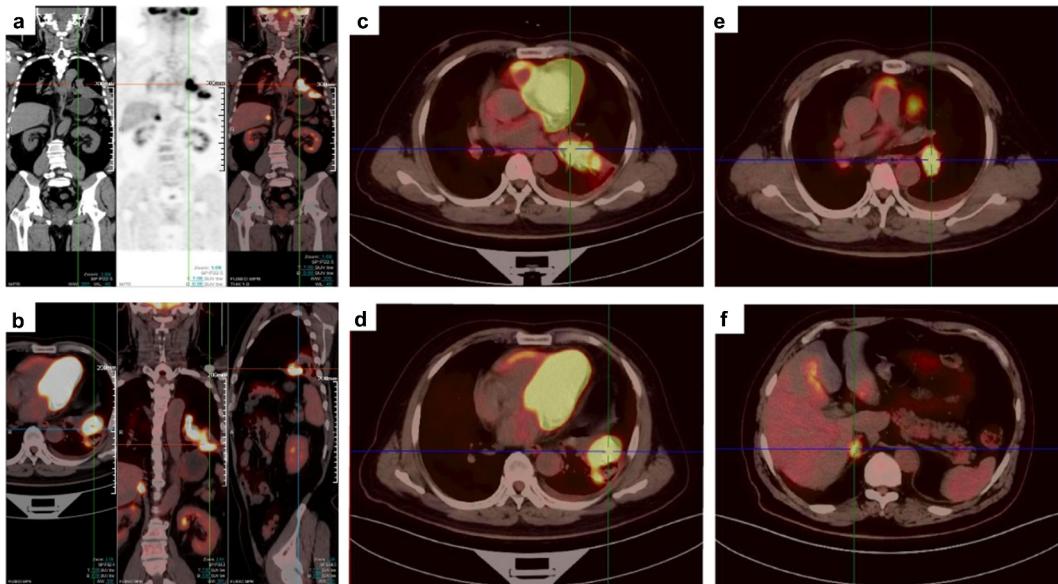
PET/CT examination at baseline. (a–b) Coronal imagings of tumor including soft tissue mass in the left lower lobe, lymph node metastasis and right adrenal metastasis. (c–d) Primary tumor at the left lower lobe. (e) Left pulmonary hilar lymph node metastasis. (f) Right adrenal metastasis.
